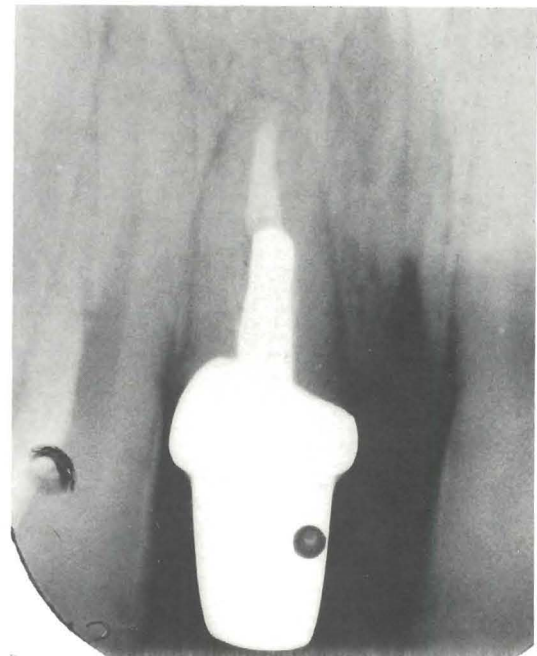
The one-year control. Periapical healing is completed. The periodontal ligament was intact around the entire root.
